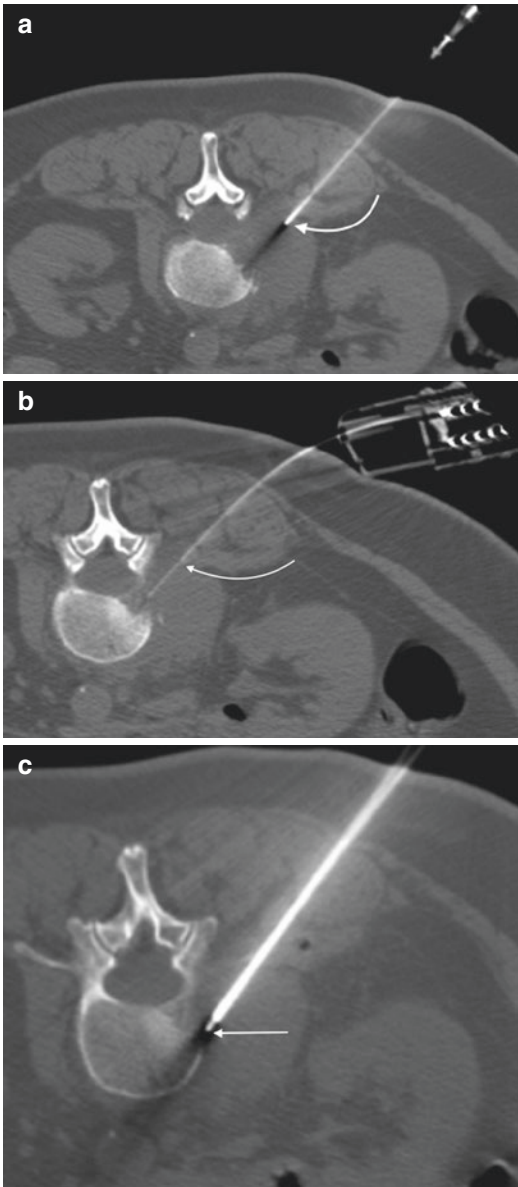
A 63-year-old female with low back pain and abnormal MRI and CT examinations showing an L2 lesion. Axial CT image (a) showing FNA of paraspinal soft tissue mass (arrow). Axial CT image (b) shows soft tissue core needle biopsy (arrow) (note the top-heavy bulky handle). Axial CT image (c) shows bone biopsy of the L2 vertebra (arrow)
